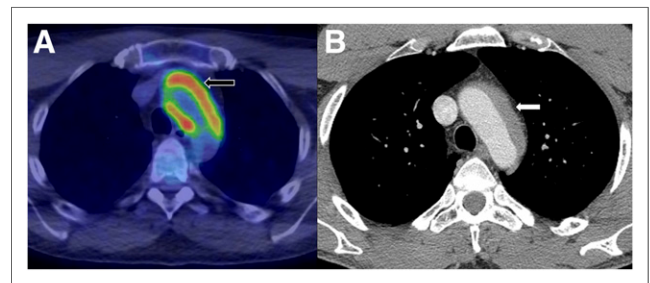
(A) Axial fused ^{18}F -FDG PET/CT of thorax demonstrates intensely ^{18}F -FDG-avid soft-tissue thickening surrounding aortic arch (arrow). (B) Corresponding contrast-enhanced CT demonstrates asymmetric soft tissue involving aortic arch in expected region of adventitia (arrow).
